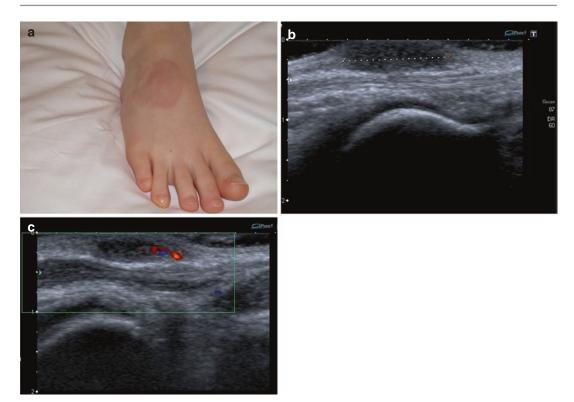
Granuloma annulare in a young child: (a) clinical image. Note a reddish discolored annular plaque over dorsal aspect of foot; (b) longitudinal ultrasound; (c)
